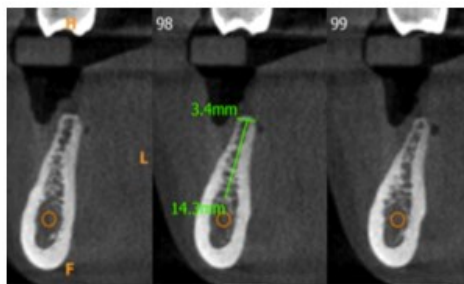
Presurgical radiograph
